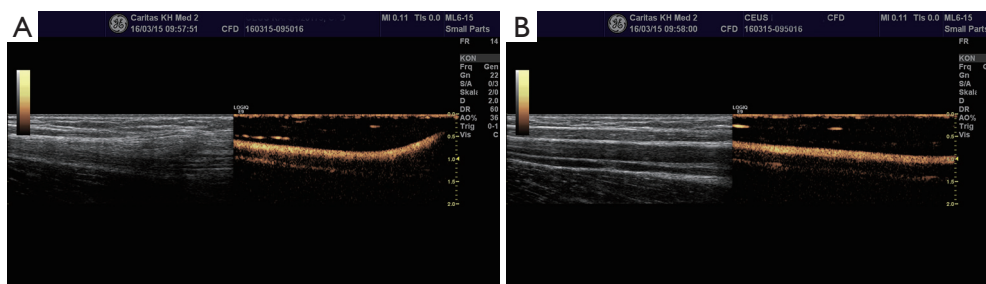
Proof of intravascular position of a venous catheter using contrast-enhanced ultrasound. (A) Site of catheter insertion; (B) delineation of the vessel lumen by the injected contrast agent.
